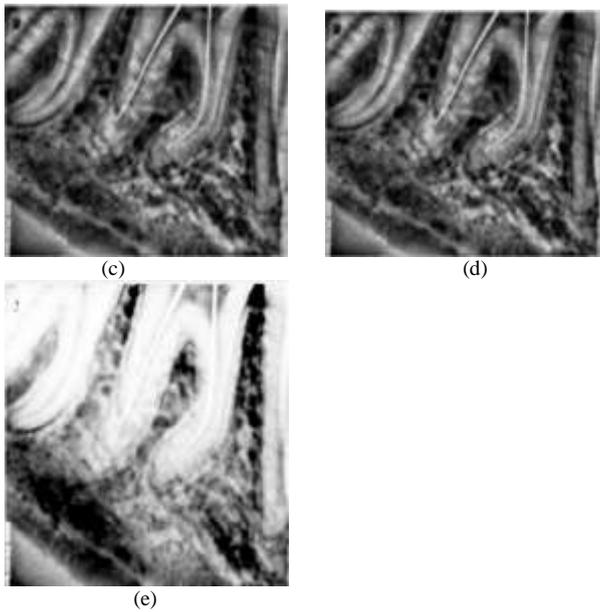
(a) Dental pre-molar tooth with double roots CBCT input image (b) Output image after Histogram (c) Output image after CLAHE (d) Output after MSR (e) Output after Fuzzy enhancement.
